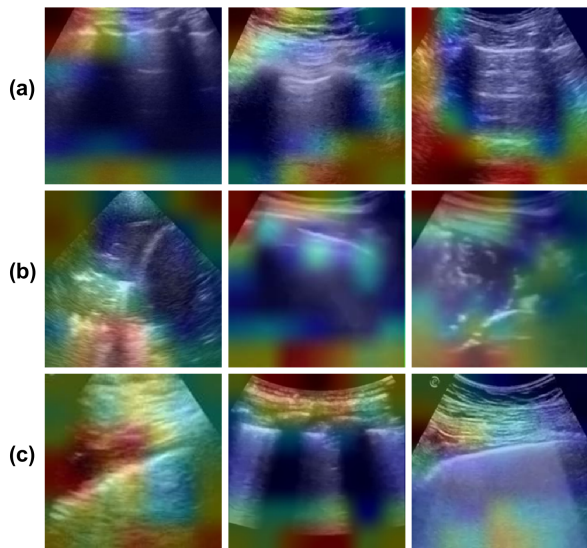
Example lung ultrasound images after the visualization using the Grad-CAM utilized in this work representing classes (row-wise) of (a) Healthy lung, (b) Pneumonia infected lung, and (c) Lung infected with COVID-19 exhibiting pleural irregularities and small subpleural consolidation.
